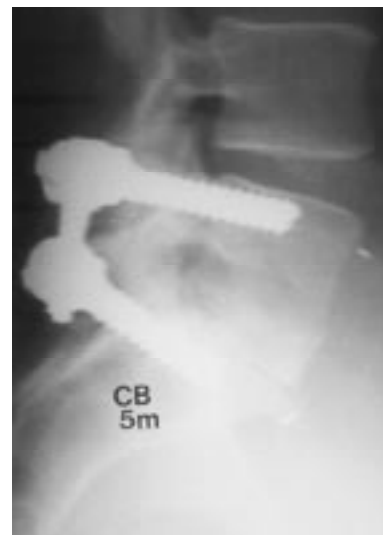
Lateral x-ray of circumferential fusion L5-S1 with femoral ring allograft anterior and pedicle screws and rods posterior.
